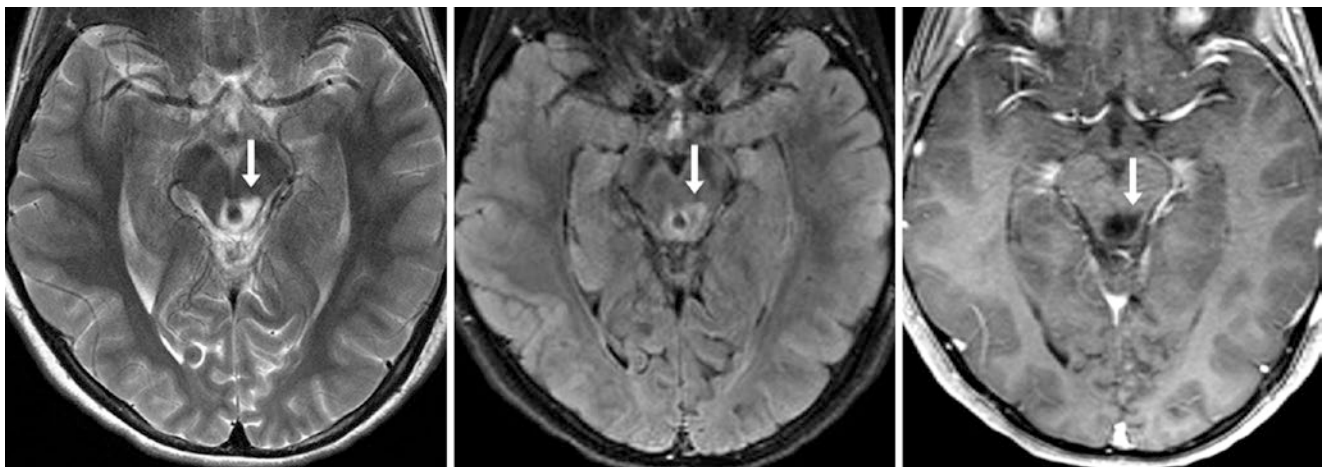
Comparison case of low-grade glioma. A 15 year old had a hyperintense abnormality (arrows) on a 3T MRI with T2WI (left) and FLAIR (middle); the lesion surrounded the aqueduct, involving the left
